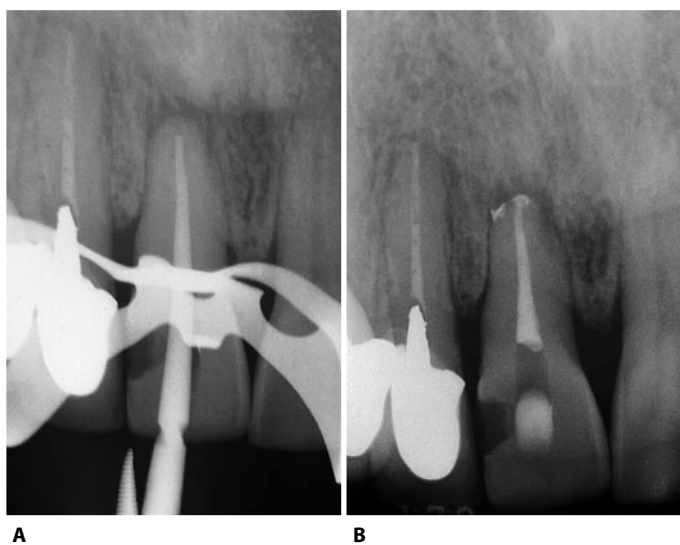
A. Intraoperative radiograph of the cone fit in an upper central incisor: the canal is wide and straight; therefore, the cone is shortened by about 2 mm. B. Postoperative radiograph: during the vertical compaction, the cone has moved to the end of the preparation. A lateral canal has been filled, with a good apical control of the obturating material.
